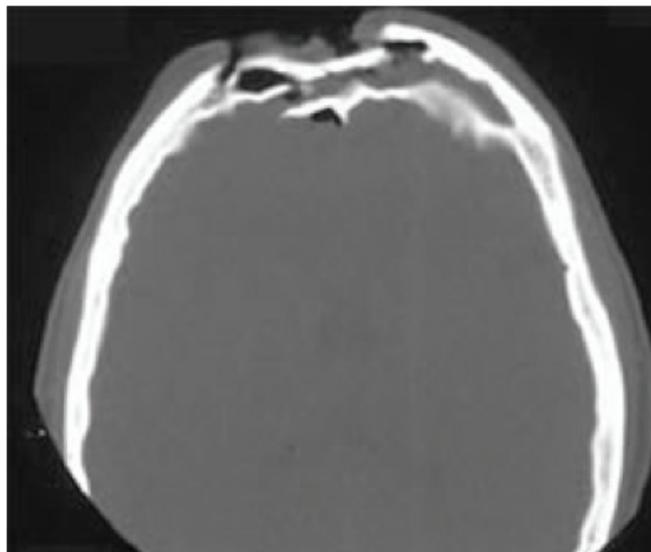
An axial CT image of a posteriorly displaced frontal sinus fracture. Fracture displacement of the posterior wall of the frontal sinus with cerebrospinal fluid leakage or a foreign body lodged in the frontal sinus is an indication for surgery.
